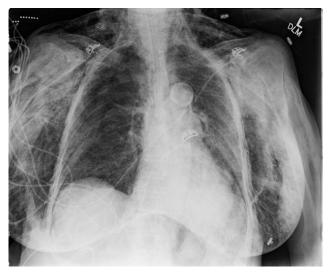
$CO_2$  cryotherapy-induced esophageal perforation with bilateral pneumothorax and extensive subcutaneous emphysema on chest radiograph.
